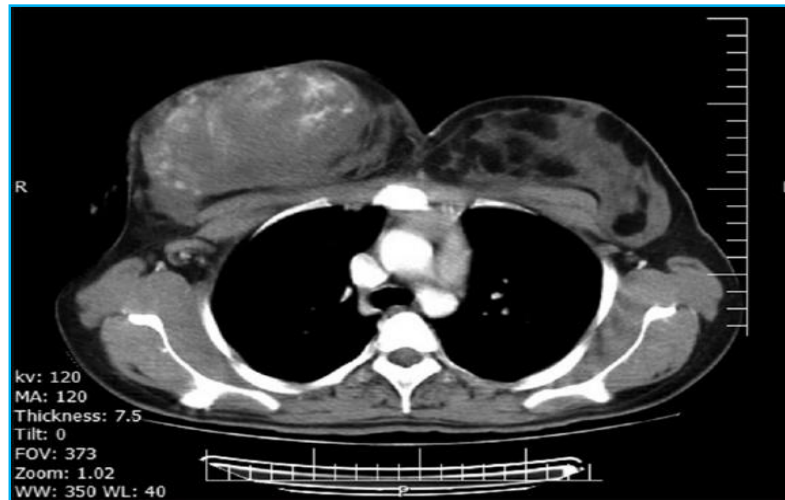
15 CT image of breasts.
